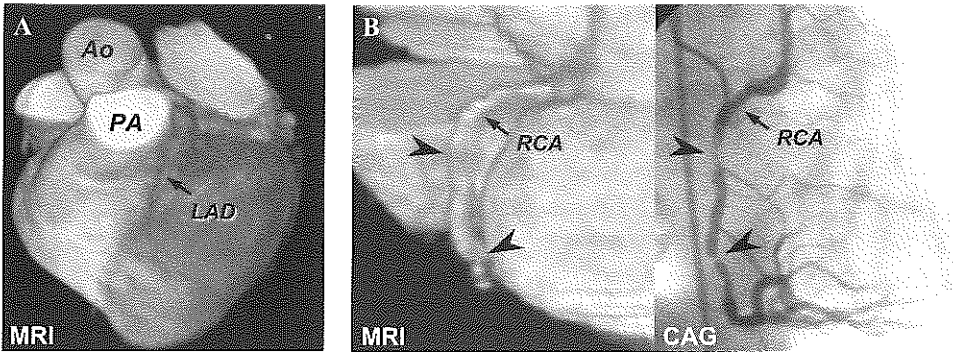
(A) Patient with severe image blur in MRI due an irregular respiration pattern. The left anterior descending coronary artery (LAD) can hardly be differentiated from its surroundings. Ao = Aorta, PA = Pulmonary artery. (B) Example of false-negative interpretation of a diseased mid right coronary artery (RCA) segment. In the MRI image (left image) there is insufficient sharpness to detect the stenoses (arrow heads) visible in the conventional coronary angiogram (Right sided image)
